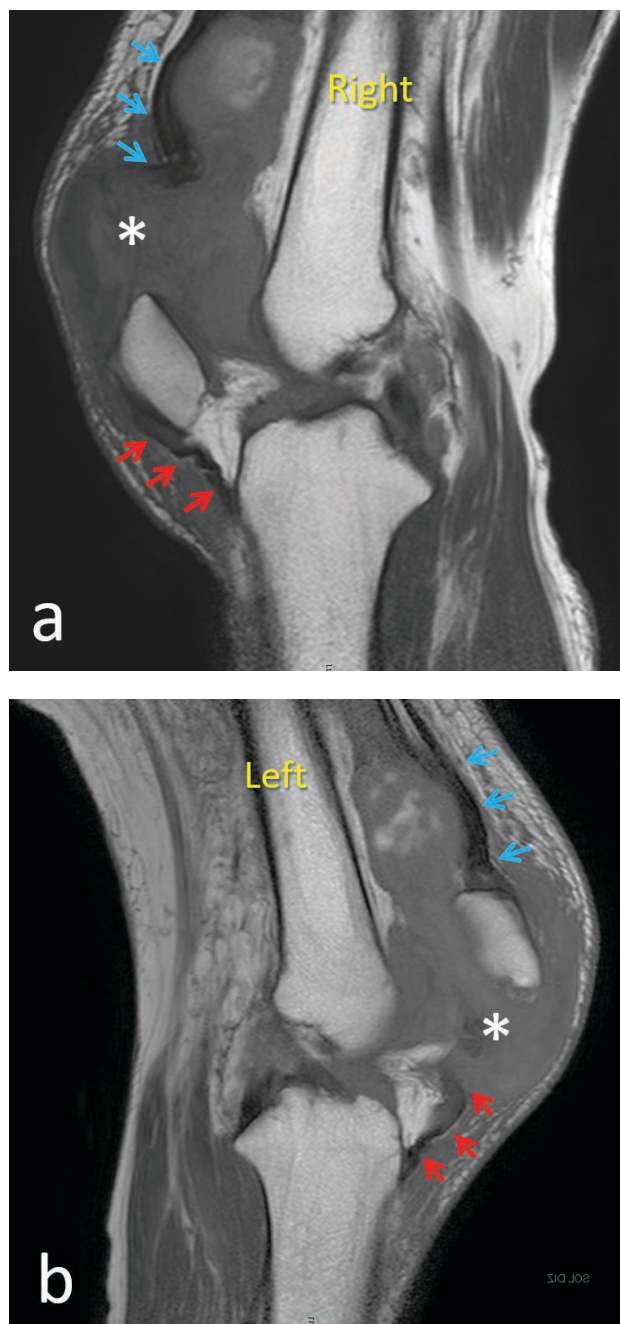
T1 weighted sagittal MRI of right and left knees. Asterix denotes the site of ruptures. Blue arrows show the QT, and the red arrows show the patellar tendon on both sides.
